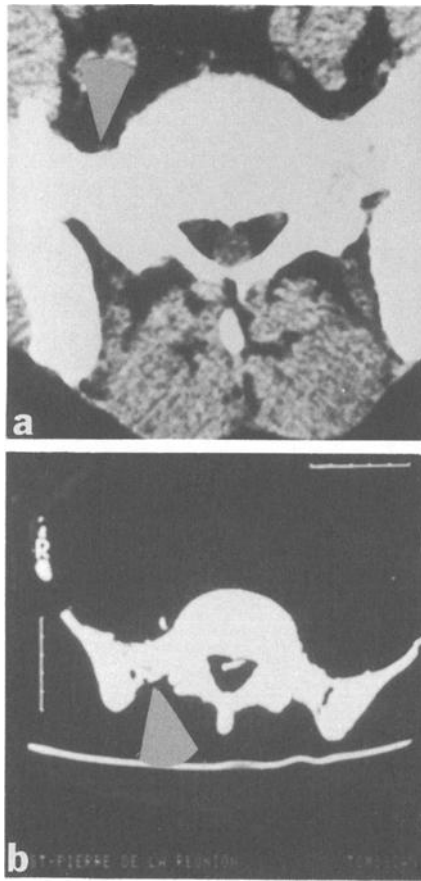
Case 1: the *partes laterales sacri* are directed forwards and outwards on the antemortem CT scan (a), whereas they are directed backwards and outwards on the postmortem image (b).
